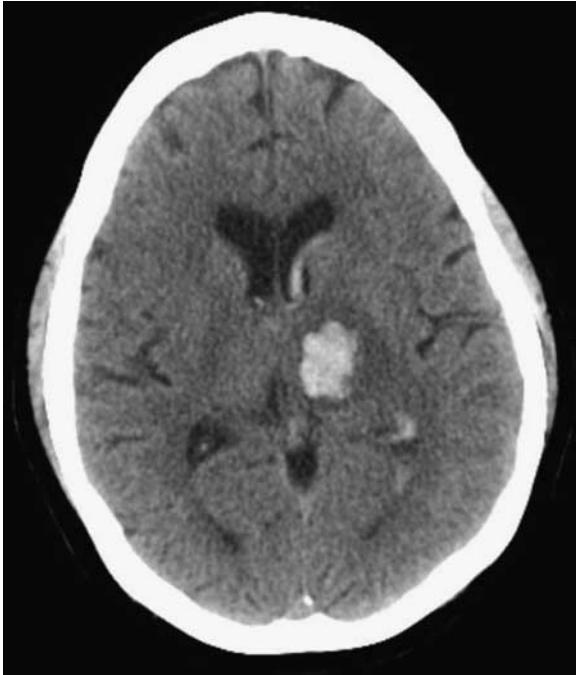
Initial head CT showing the left thalamic and intraventricular hemorrhage.
